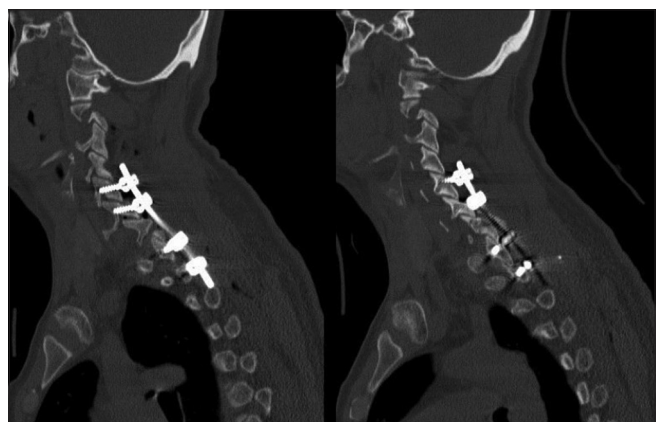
Postoperative sagittal computed tomography scan of the cervical spine demonstrating complete reduction of the deformity (C7 flexion-distraction injury) by posterior spinal fixation with C5 and C6 lateral mass screws and T1 and T2 pedicular screws insertion. The reduction of the deformity has resulted in normal cervical spine alignment and intact canal
